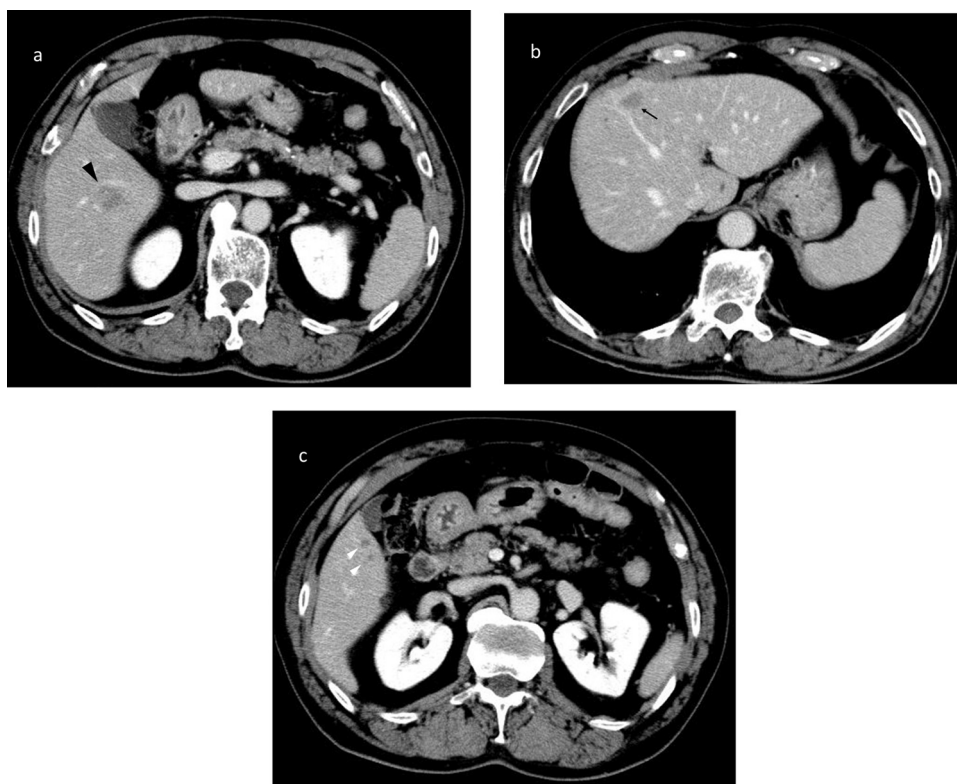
Abdominal CT showed (a) a peripherally enhanced 3.5-cm mass in liver segments V/VI (black arrowhead) and (b) a peripherally enhanced 1.5-cm mass in segment IV (arrow). (c) CT also showed unenhanced masses in segments I, IV, V, and VII (white arrowhead).
